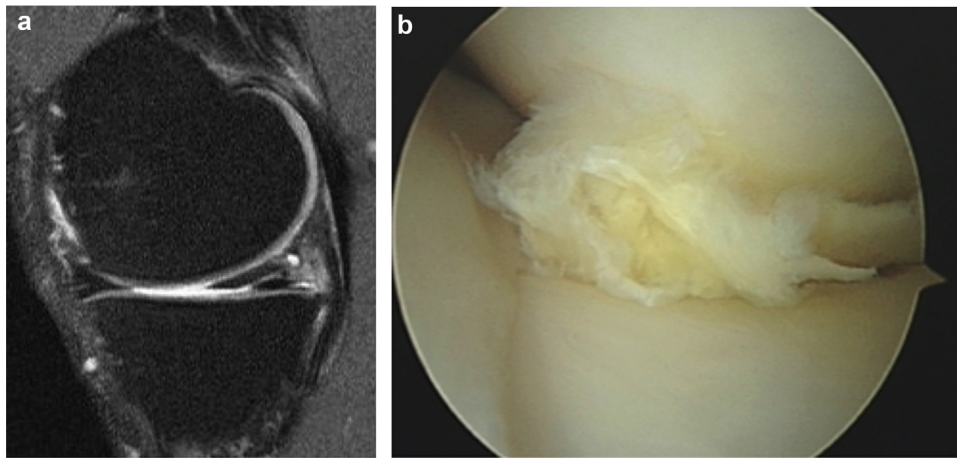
Degenerative meniscal lesion. a: typical grade-3 medial meniscus aspect on MRI; b: arthroscopic aspect.
